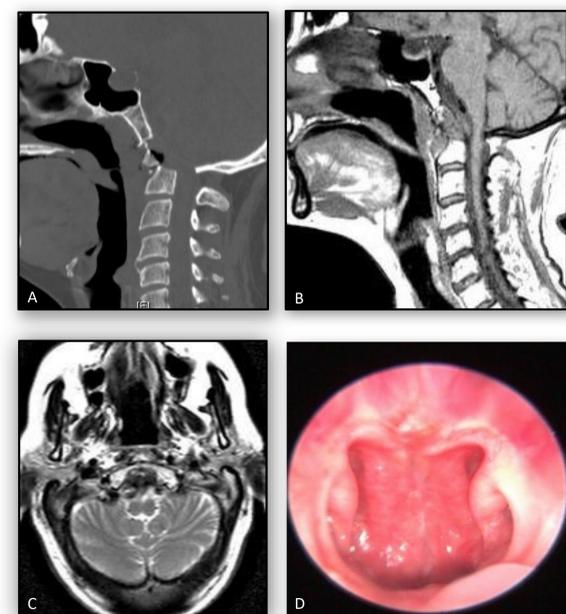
postoperative neuroimaging studies show partial odontoidectomy in postop CT scan (A), adequate spinal cord decompression and rheumatoid pannus removal in sagittal T1 MRI (B) and axial T2 MRI (C). Mucosal flap at one month endoscopic evaluation (D).
